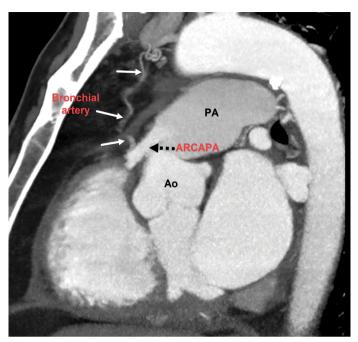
Coronary computed tomography angiography with a multiplanar reconstruction image shows a bronchial-coronary artery fistula between the hypertrophied bronchial artery and the proximal part of the anomalous right coronary artery from the pulmonary artery
